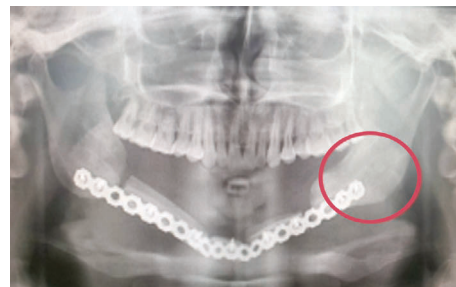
Panoramic radiograph showing only a small amount of bone in the alveolar ridge remaining in the left mandibular molar region (red circle).
